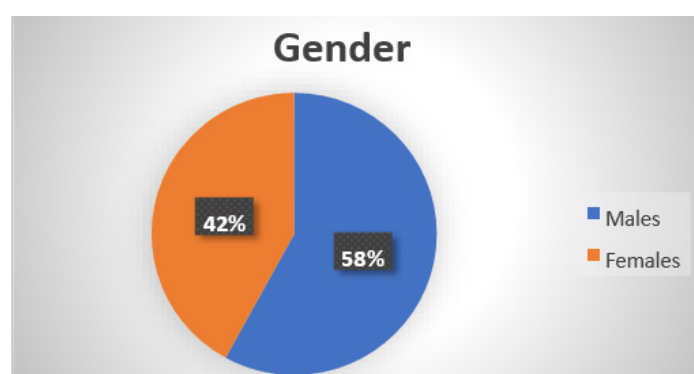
Sex distribution of abnormal chest radiographs, 178 males and 129 females expressed in percentage
